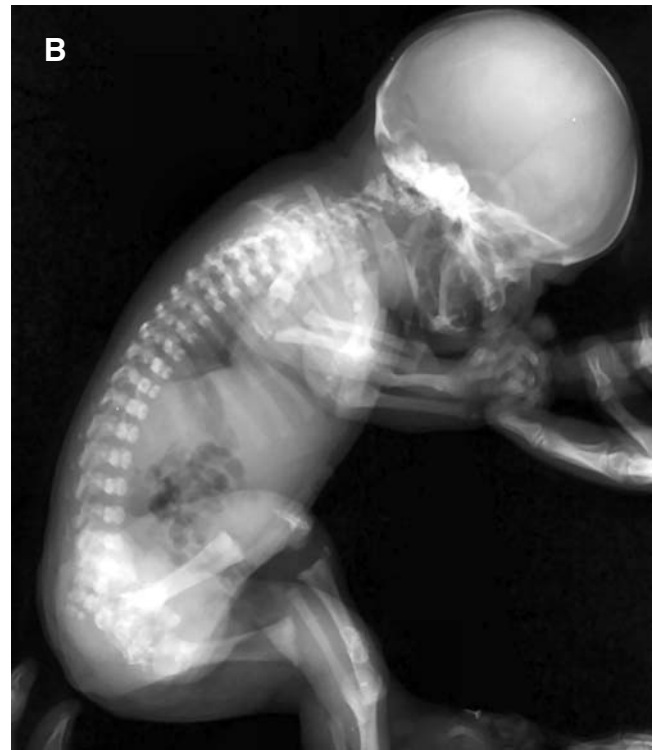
Plain radiographs: *A* shows symmetric bilateral shortening and metaphyseal widening of the humerus and femur with punctate calcifications of epiphysis of the long bones and the pubis, and *B* shows coronal clefts in the vertebral bodies.
